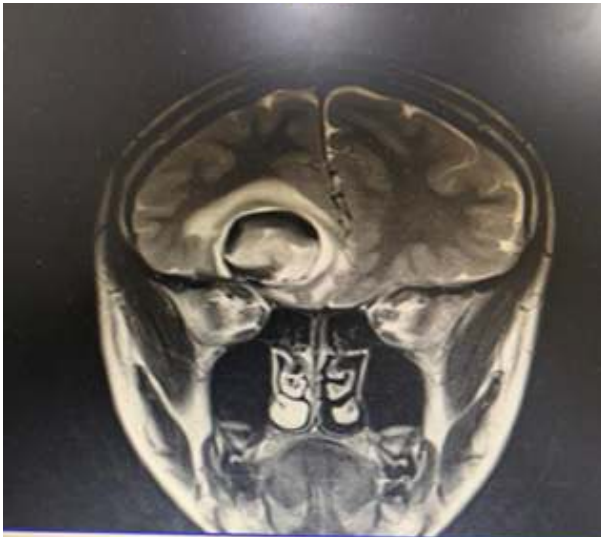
Magnetic resonance imaging of the brain showing Zabramski cavernoma 1.
